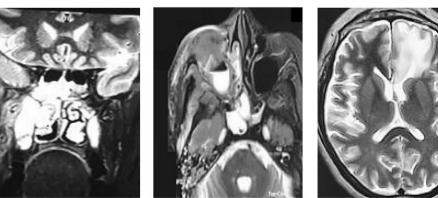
a–c Coronal and axial Gadolinium enhanced magnetic resonance imaging scans of paranasal sinus, orbit and brain showing involvement of all sinuses along with extension into orbit and brain
